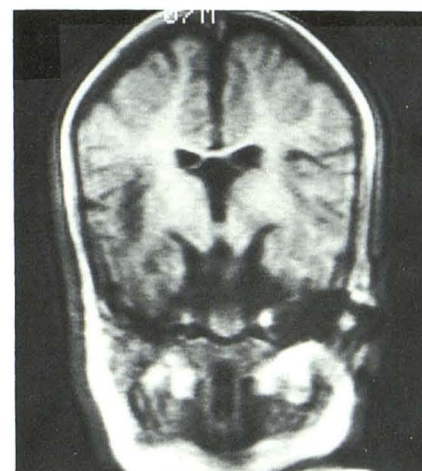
Spin-echo coronal MR image (TE = 28/TR = 500) of 15-month-old boy shows cortical atrophy and increased ventricular size.
